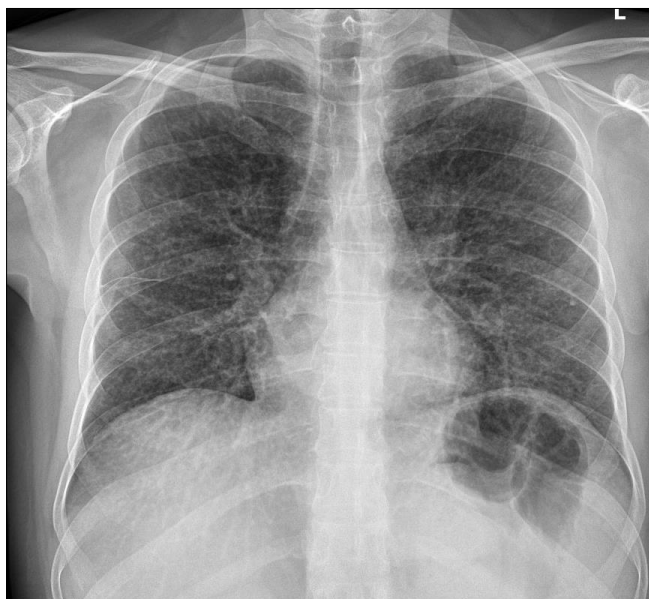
Posteroanterior chest radiograph: bilateral perihilar predominant reticular thickening of the pulmonary interstitium
